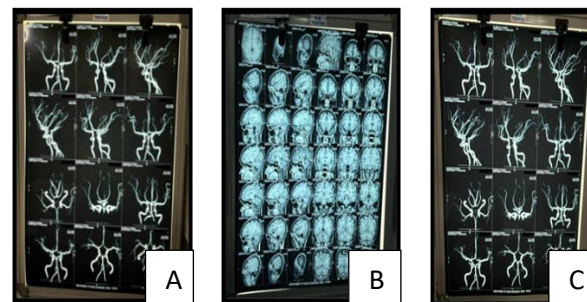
(A-C): MRI with MODSA sequence images.
